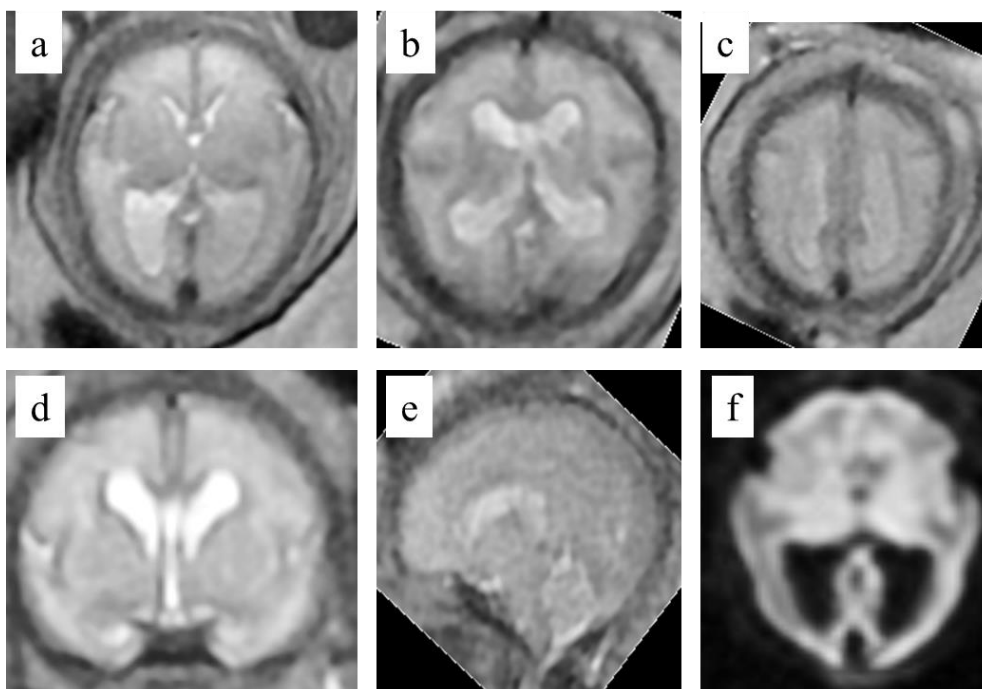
A fetus with brain injury presumed secondary to chorioamnionitis. The pregnancy was complicated by premature rupture of the membranes at 28gw followed by reduced fetal movements and iuMR imaging at 29gw. Axial (9a-9c), coronal (9d) and sagittal (9e) T2-weighted images shows generalised brain swelling and restricted diffusion (9f). Cardiac activity was present at the time of imaging but the fetus was stillborn the following day. A presumptive diagnosis of inflammatory brain injury secondary to chorioamnionitis was made.
